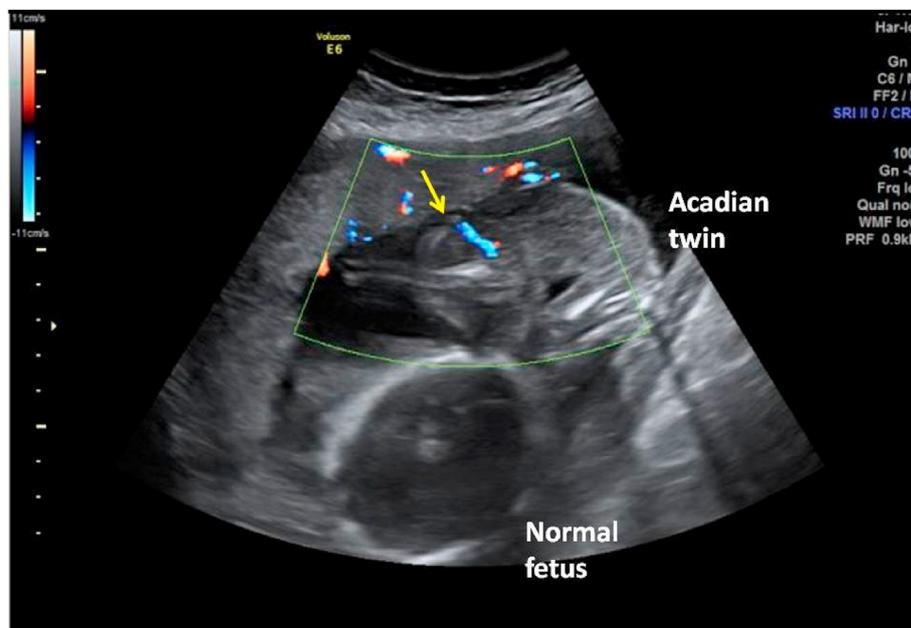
Ultrasonography showing malformations in the twin fetus (Arrow points to the malformation connected vessels, consistent with the figure 3-1 grossly picture).
